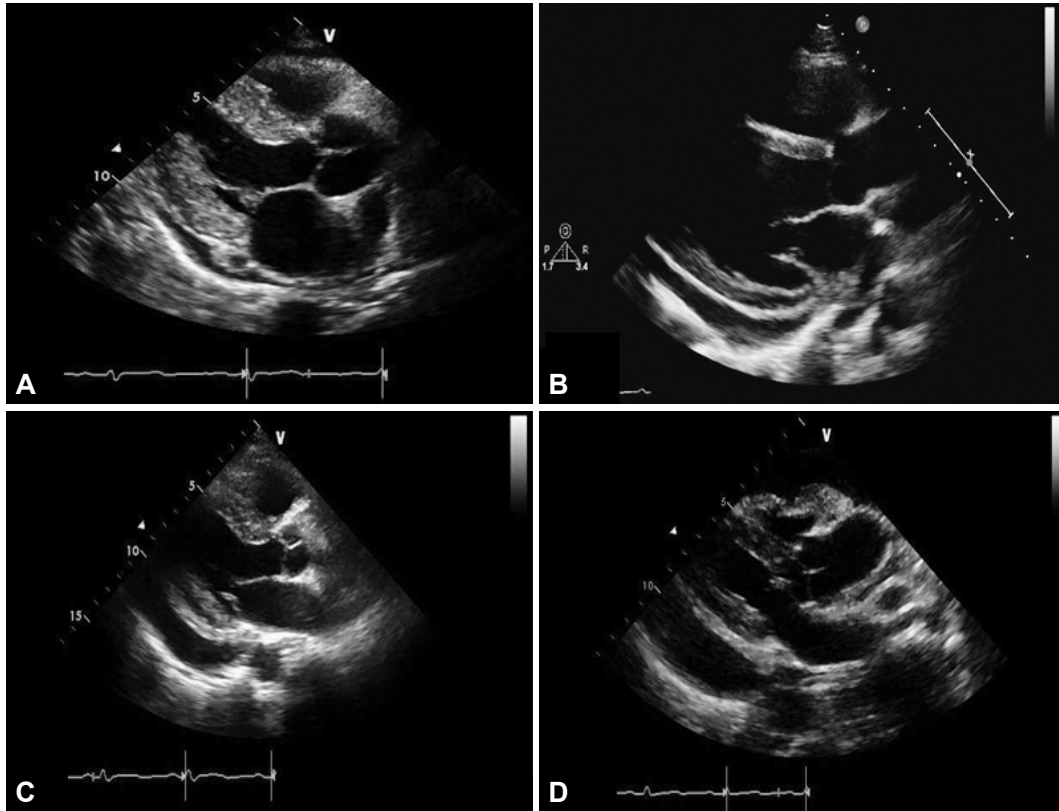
Echocardiographic grading of pericardial effusion as scanty (A), mild (B), moderate (C), and large (D).
